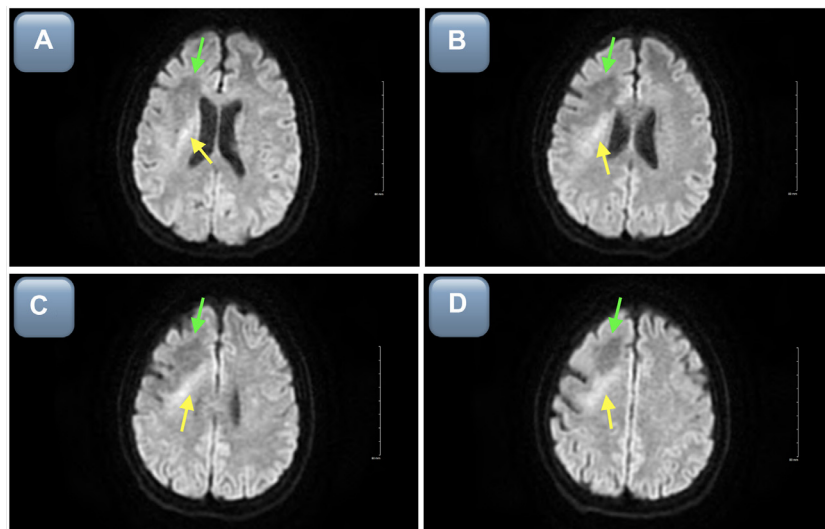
Axial noncontrast T1-weighted (A-D) and post-contrast T1 (E-H) MRI brain in a 40-year-old female showing hypointense subcortical and periventricular white matter in the right frontal and parietal lobes with defined margins (green arrows), partly hyperintense right frontal cortex and insula (yellow arrows), and no significant contrast enhancement. These findings are significant for PML with laminar necrosis.
